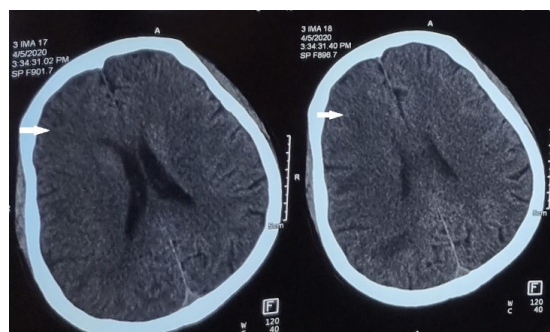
Postoperative brain CT (Arrow indicates infarction area)
